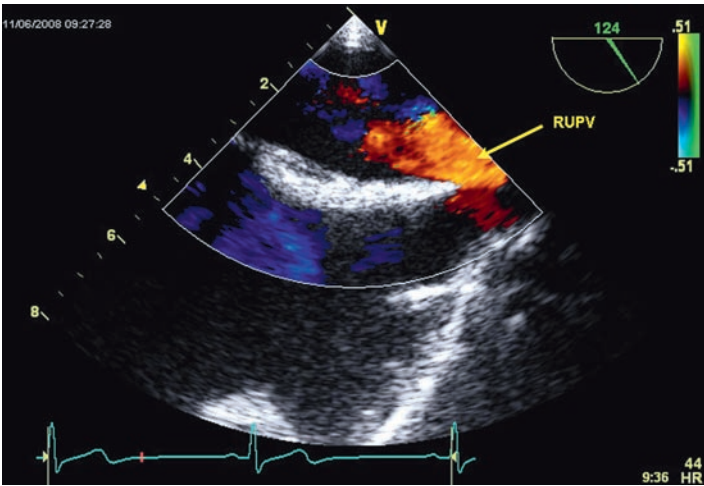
The bicaval view with superadded manual rotation of the probe clockwise/to the right. Color Doppler demonstrating right upper pulmonary vein (RUPV) inflow (red).
